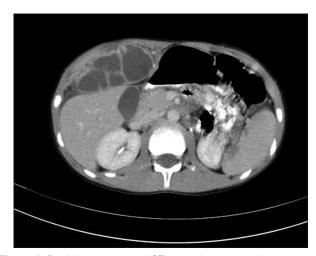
Double contrast axial CT scan showing a multicystic mass with thick and enhanceable septa in the right subphrenic region and hypodense lesions in the spleen
